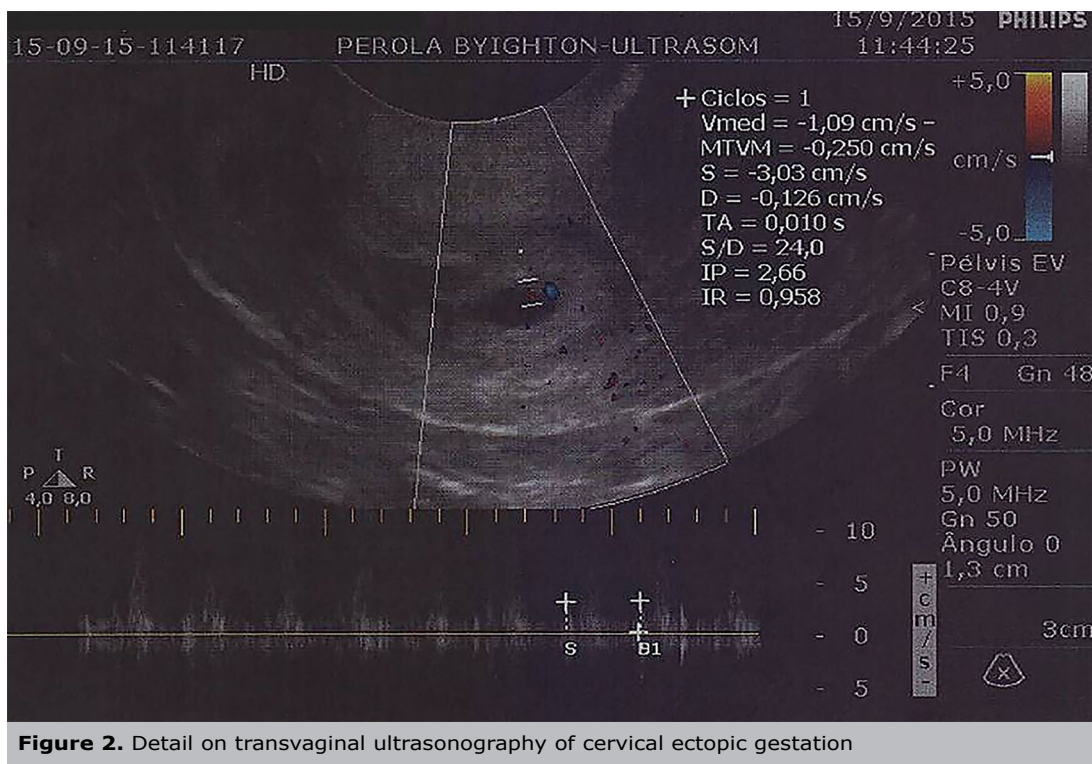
Detail on transvaginal ultrasonography of cervical ectopic gestation
